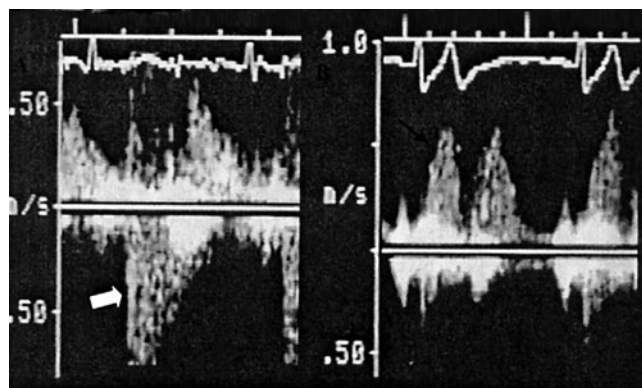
Pulsed-wave Doppler of pulmonary venous flow in two cases of mitral regurgitation. (Left) There is a systolic flow reversal (negative flow in systole, large arrow) consistent with severe mitral regurgitation (MR) and a large *v* wave on the left atrial pressure. (Right) There is a normal forward flow (positive flow in systole, thin arrow) suggestive of the absence of a *v* wave. The systolic pulmonary venous flow reversal is a specific sign with high positive predictive value but of low sensitivity for severe MR.
